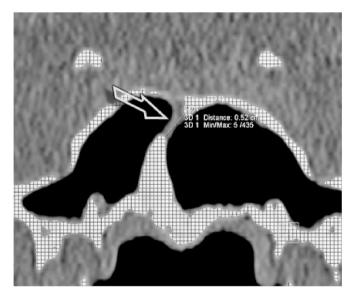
CT of the paranasal sinuses, coronal plane. A partially membranous septum (the membranous part of the septum is measured on the image).
